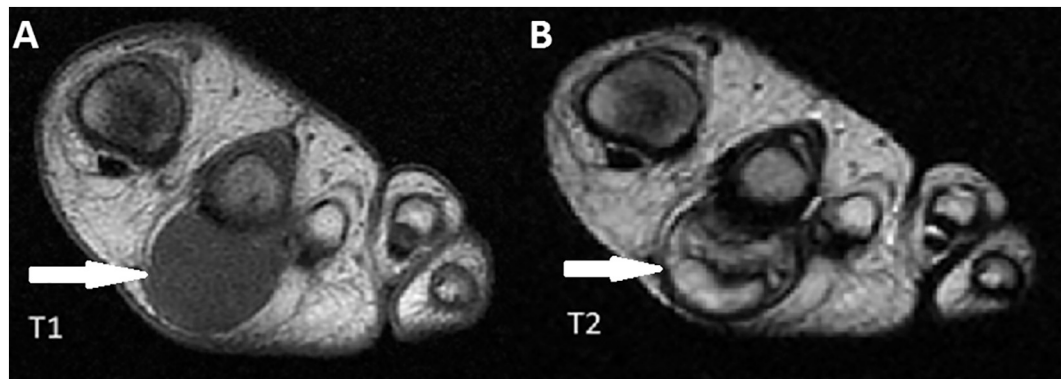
Transverse MRI views showing a soft tissue mass measuring 37 * 27 mm with regular seams on iso-signal T1 (A) and hyposignal T2 (B) (white arrows).
